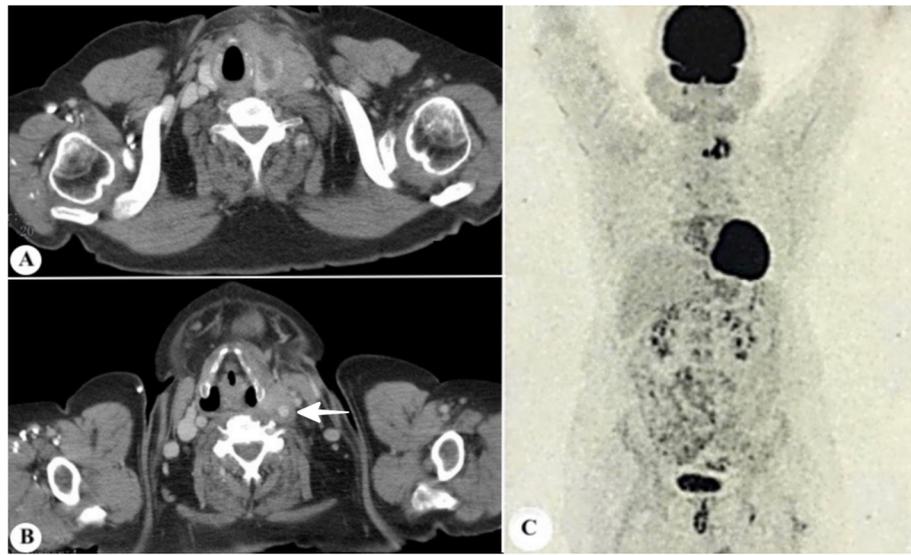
a, b Contrast-enhanced CT scan of the neck, axial views, showing a mildly enhancing soft tissue involving the left lobe of the thyroid and adjacent strap muscles and b "pericarotid cuffing" of the common carotid and internal carotid artery (arrow) with the lesion. The internal jugular vein is not visualized because of compression by the mass lesion; however, there is no evidence of carotid stenosis. c Whole-body FDG-PET scan showing increased uptake in the left thyroid/perithyroid region (arrow) without any abnormal uptake elsewhere in the body
